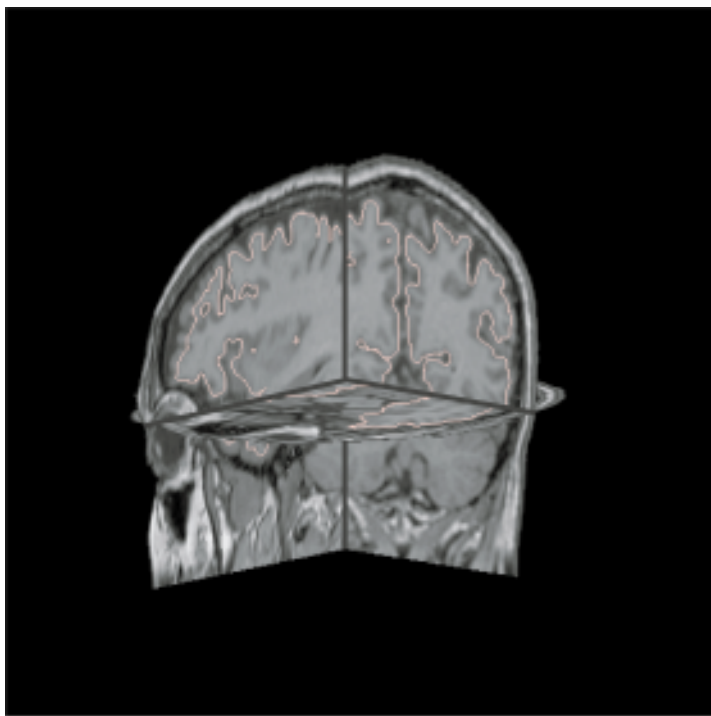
A view of the intersection between the deformable surface and orthogonal slices of the MR image.
